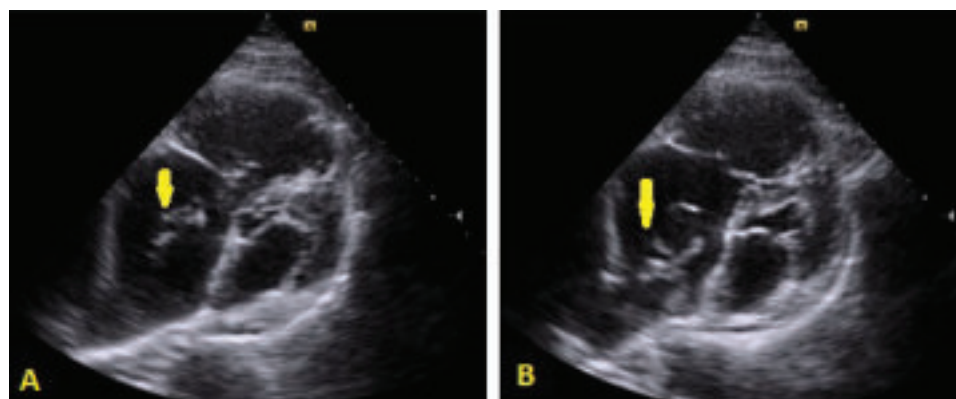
Panel A & B: 2D echocardiography of a case of pulmonary thromboembolism showing Chiari network in dilated right atrium in different phases of off-axis views marked by yellow arrows.
